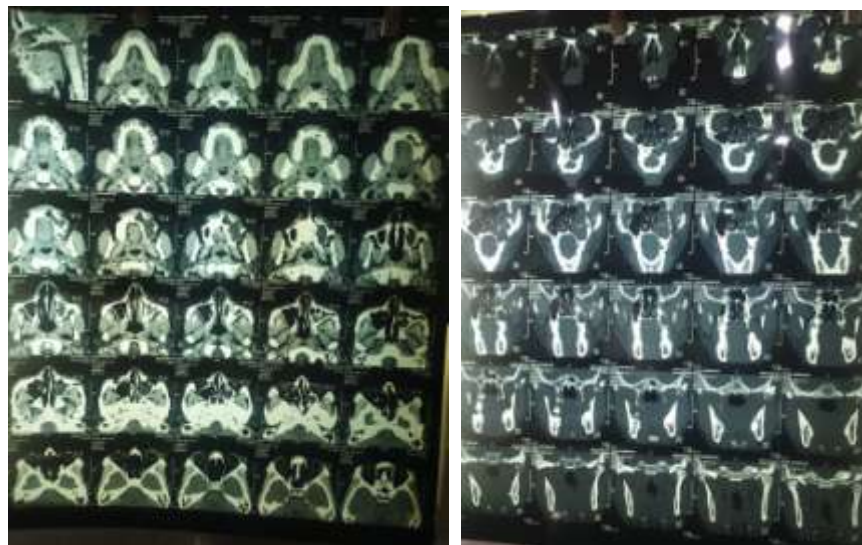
4 & 5:- CT Scan of face.
